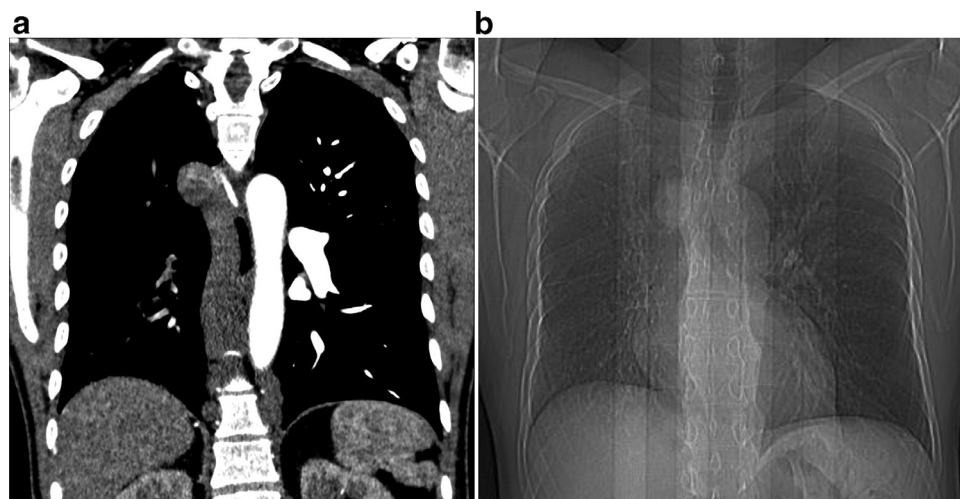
(A) Enlarged azygous vein as a continuation of interrupted infrahepatic IVC draining into SVC. (B) CT scanogram demonstrates enlarged azygous vein seen to the right of trachea, smaller right lung and right hilum.
